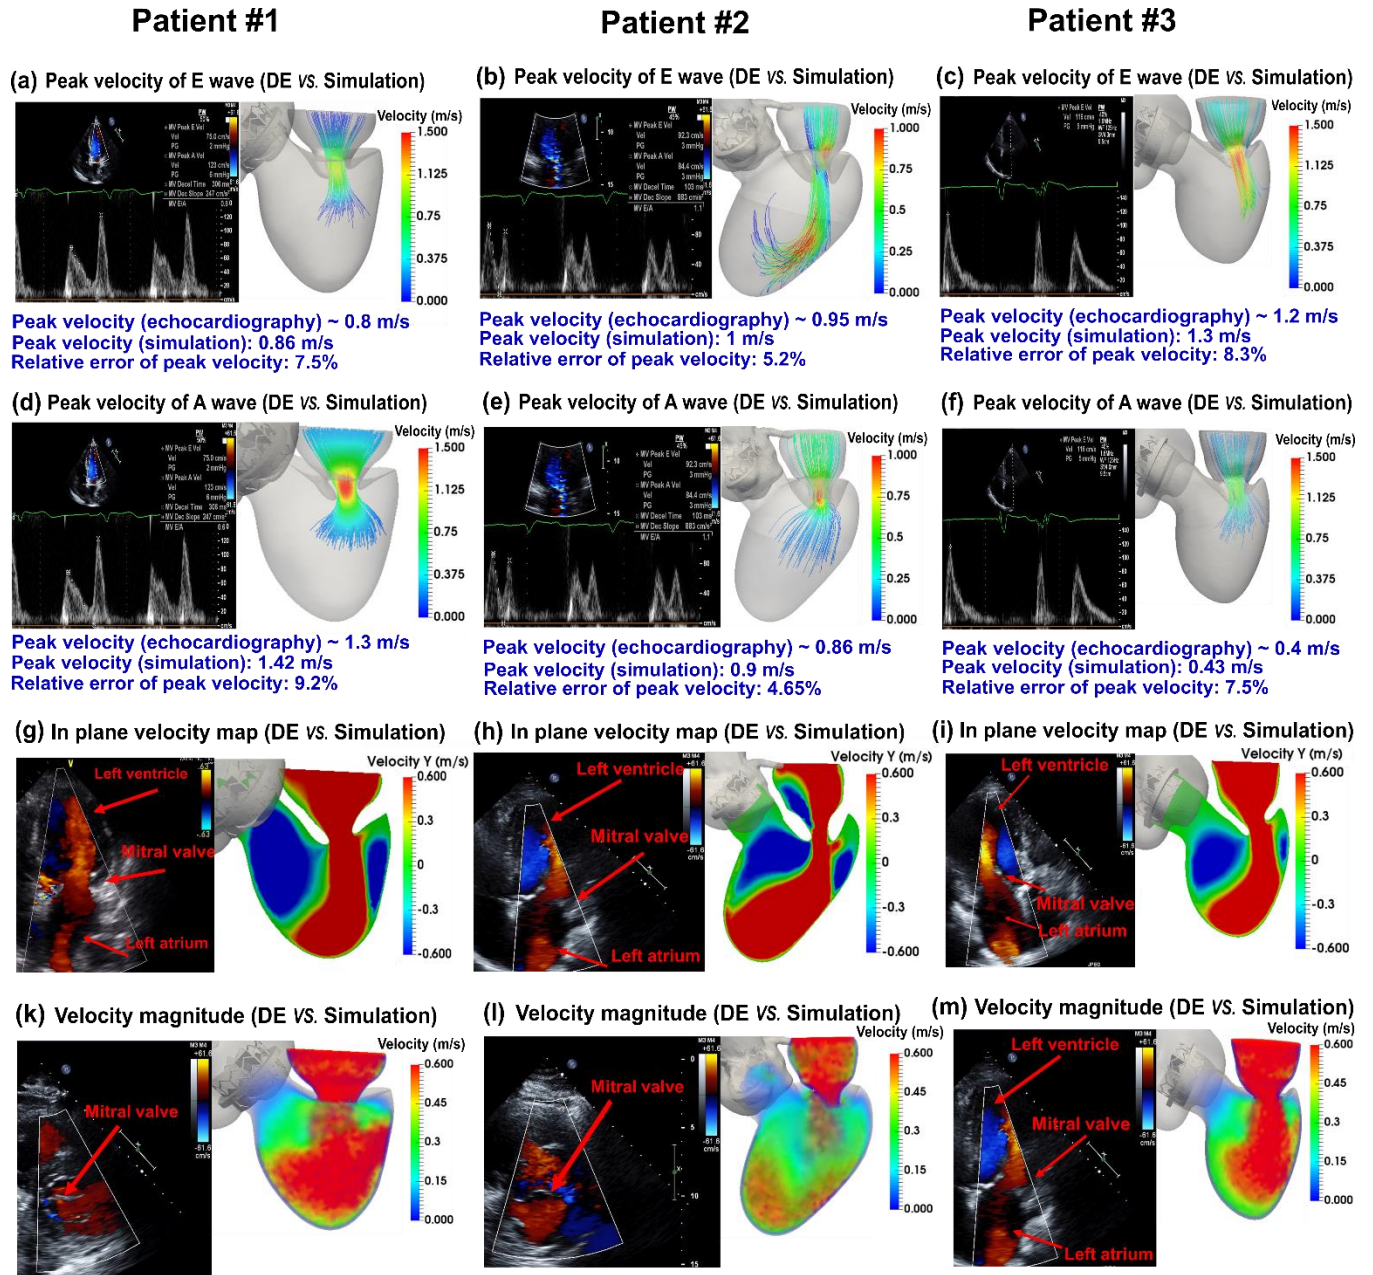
Validation: Doppler-based LPM and FSI framework vs. patients Doppler echocardiography data. (a) to (f) Trans-mitral velocity during diastole in patients #1 to #3; (g) to (i) Left ventricle flow (apical view) during diastole in patients #1 to #3; (k) & (m) Mitral valve flow (parasternal short axis view) during diastole in patients #1 and #2; (l) Mitral valve flow (apical view) in patient #3.
